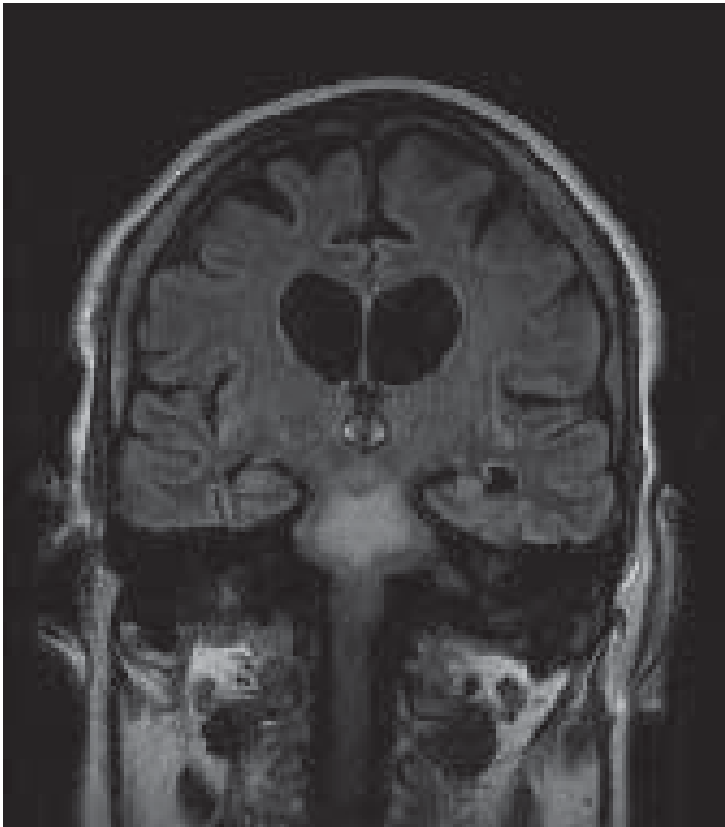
Magnetic resonance imaging demonstrating high signal in the pons consistent with demyelination.
